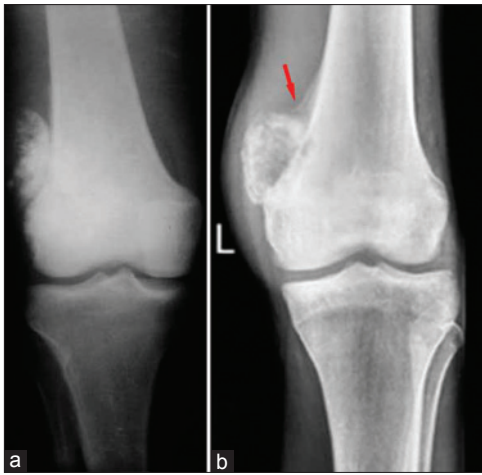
X-ray of knee joint anteroposterior views showing surface osteosarcoma: (a) parosteal (b) periosteal. See the underlying cortex is visibly intact in 'a' and lifting of periosteum in 'b' (red arrow). However, both are on the surface of the bone
